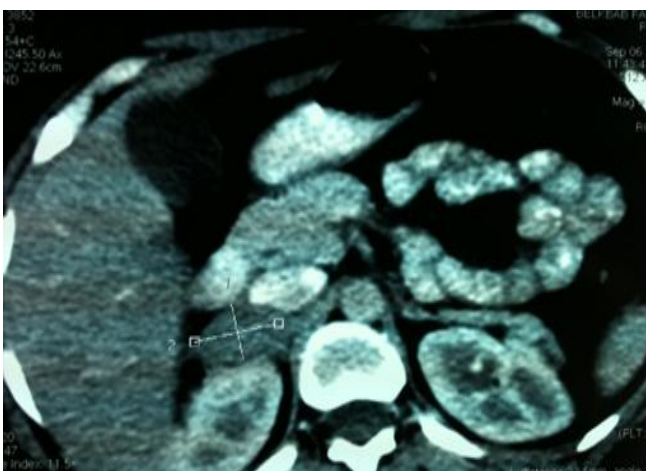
adrenal lesion on the CT scan.
